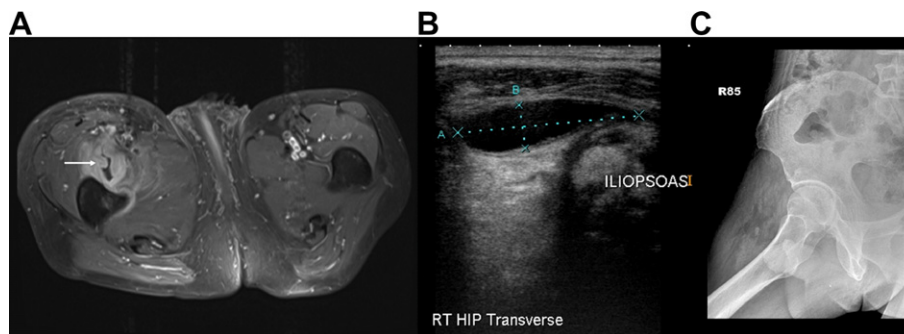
(A) Transverse magnetic resonance imaging 8 days after initial symptoms showed an intermuscular infiltrative mass-like lesion 17.5 × 5.5 × 3 mm (arrow). The area with no enhancement among edematous muscles represented the area of necrosis and hemorrhage; (B) ultrasonography and MRI were performed almost simultaneously, which showed muscle fiber disruption and also a hypoechoic mass between muscle planes; (C) the radiograph at that time did not show ectopic bone formation. MRI = * magnetic resonance imaging.
